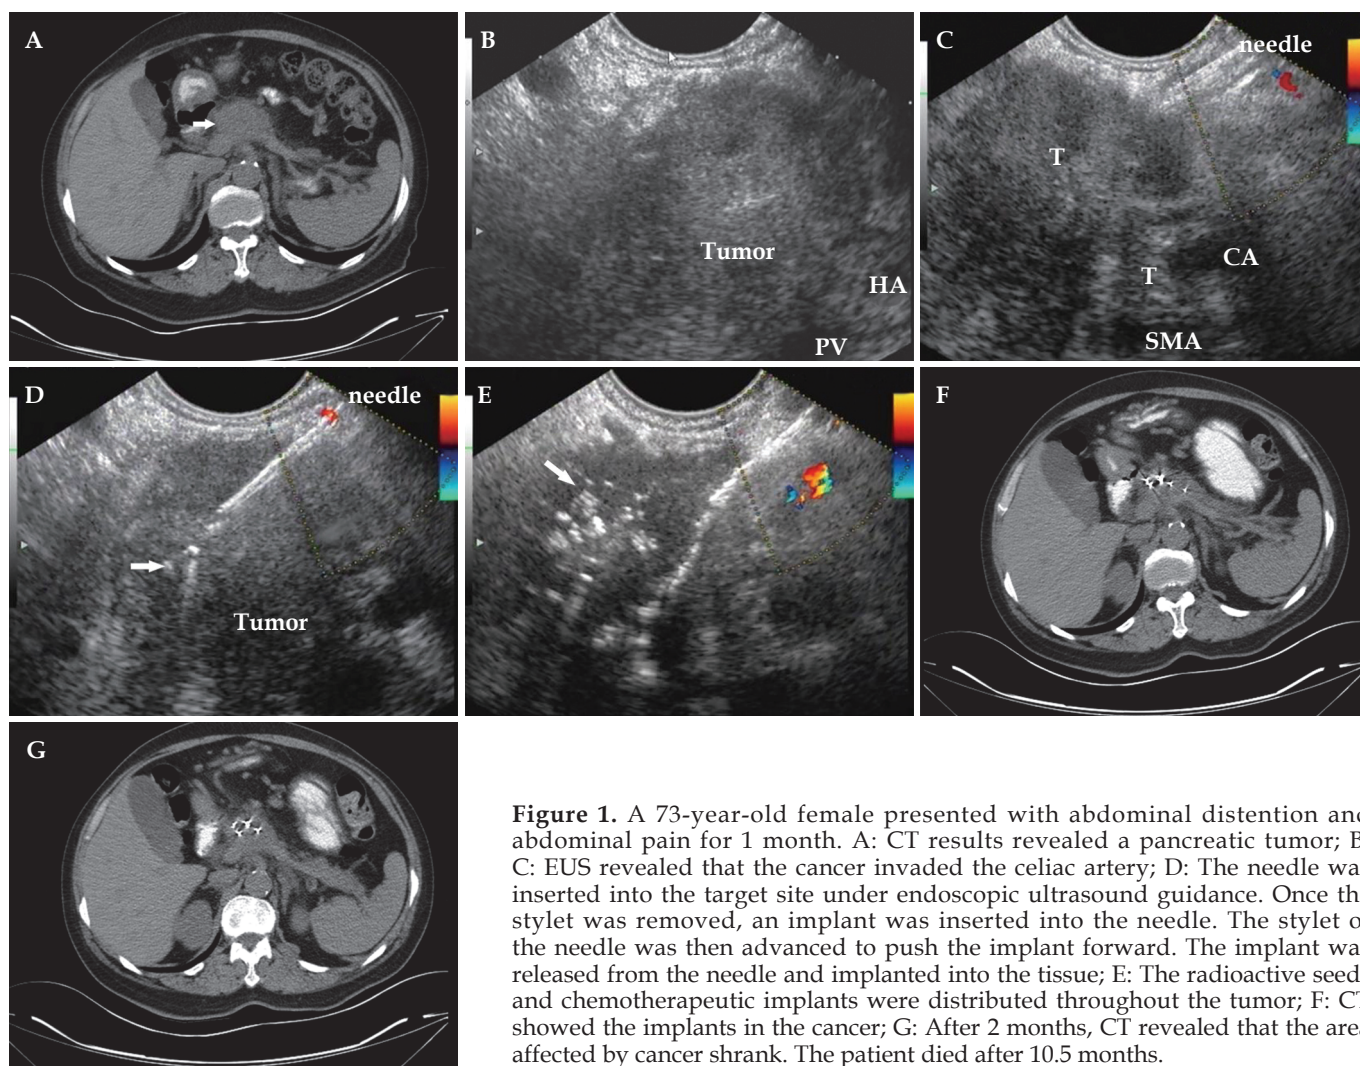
A 73-year-old female presented with abdominal distention and abdominal pain for 1 month. A: CT results revealed a pancreatic tumor; B, C: EUS revealed that the cancer invaded the celiac artery; D: The needle was inserted into the target site under endoscopic ultrasound guidance. Once the stylet was removed, an implant was inserted into the needle. The stylet of the needle was then advanced to push the implant forward. The implant was released from the needle and implanted into the tissue; E: The radioactive seeds and chemotherapeutic implants were distributed throughout the tumor; F: CT showed the implants in the cancer; G: After 2 months, CT revealed that the area affected by cancer shrank. The patient died after 10.5 months.
